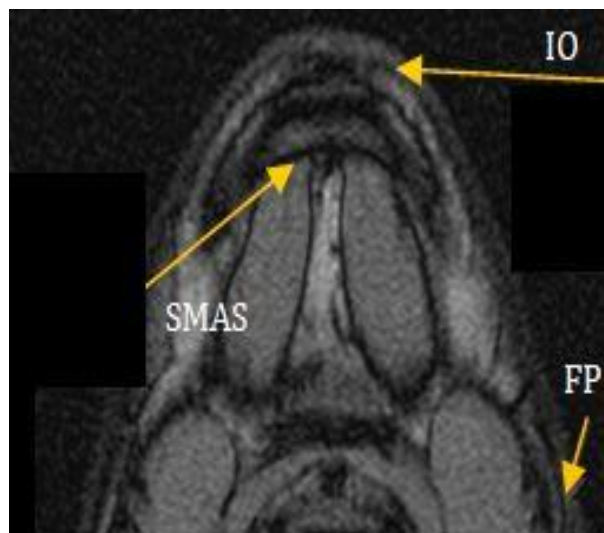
MRI horizontal section through inferior mandibular margin; SMAS and profound fascia (PF) between parotidian and mental region; TransSMAS insertion of orbicularis oris, inferior fascicle (IO).
